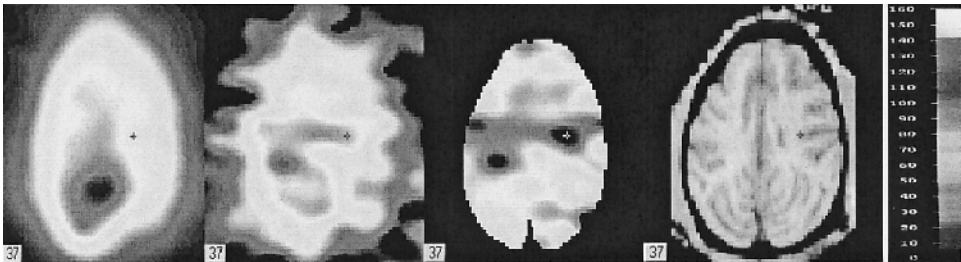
Positron emission tomography (PET) images of cerebral blood flow (CBF), cerebral metabolic rate for oxygen (CMRO₂), and oxygen extraction fraction (OEF) with a magnetic resonance image (MRI). Color scale on the right is applicable for all PET images. Right image is the right hemisphere and left image is left hemisphere.
